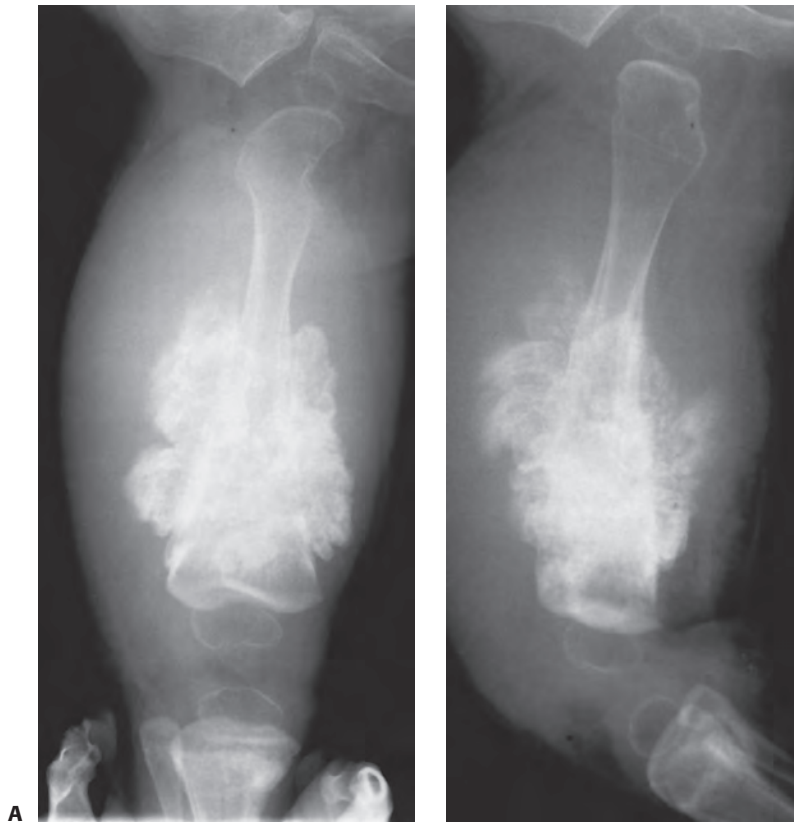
This 10-month-old boy with a history of osteogenesis imperfecta presented with a right thigh pain and swelling and refusal to bear weight. Anteroposterior (A) and lateral (B) radiographs of the right femur show the extraordinarily abundant, hyperplastic callus—with the characteristic butterfly shape—that can occur in osteogenesis imperfecta. This appearance may be mistaken for an infection or a neoplastic process.
